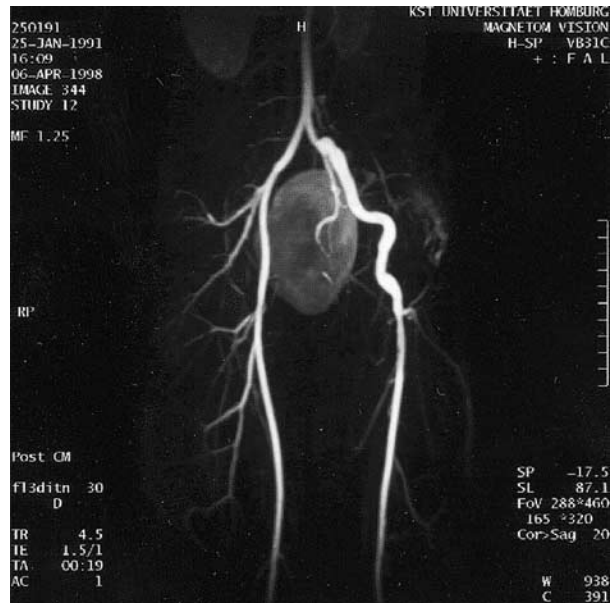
MRI angiography of postoperative result after autologous vein graft bypassing of aorto-iliac occlusion on the left side of a 5-year-old child. The vein bypass seems slightly dilated.
